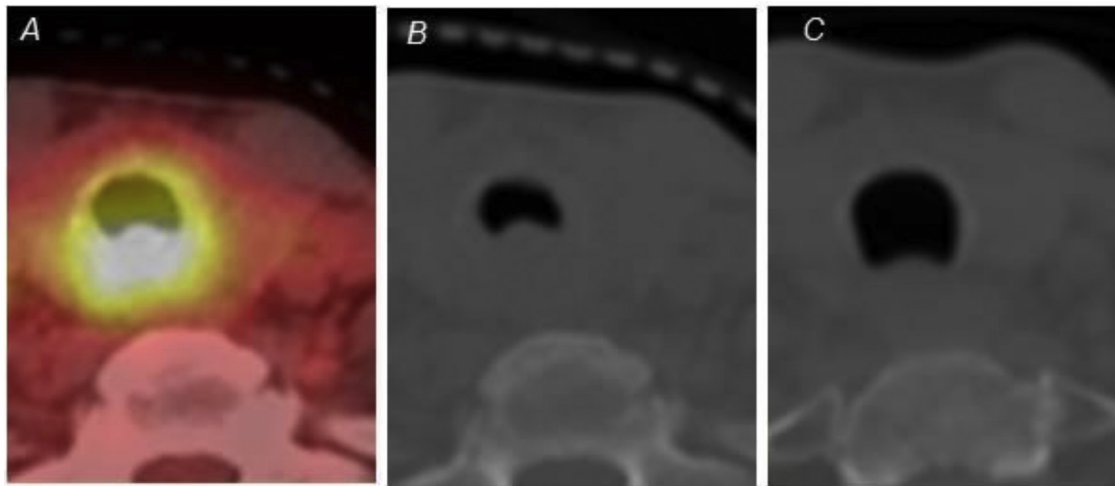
Clinical appearance of chloroma on PET (A) and CT (B) scans in patient with stridor who was treated with 24 Gy and experienced rapid symptomatic relief and radiographic response immediately after completing radiation therapy (C). *Abbreviations:* CT = computed tomography; PET = positron emission tomography.
